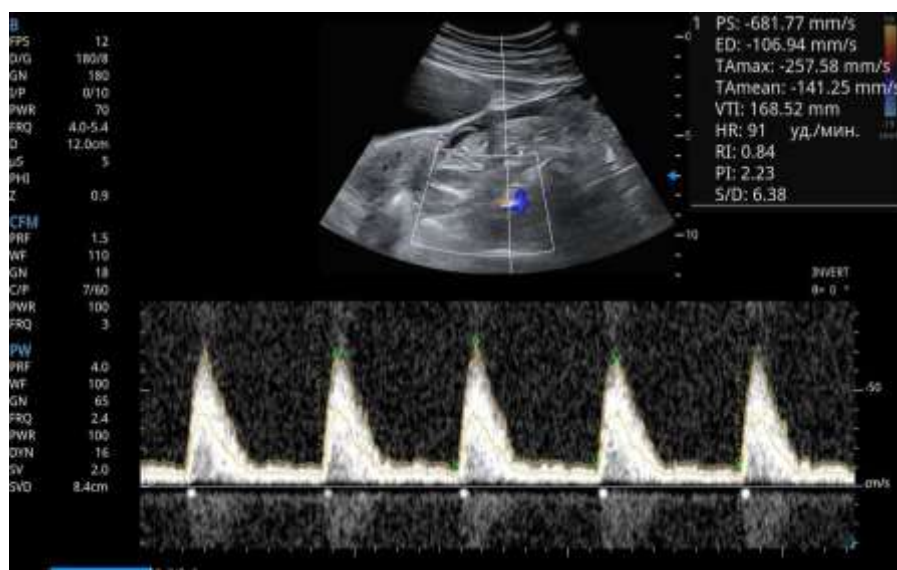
Representative pulsed-wave uterine-artery Doppler in an at-risk pregnancy showing high impedance (PI 2.23, RI 0.84, S/D 6.38).
